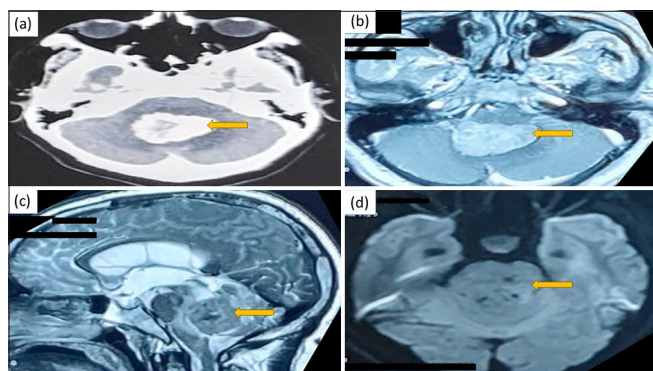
(a) Contrast-enhanced computed tomography showing a lobulated posterior fossa mass (yellow arrow) with heterogeneous enhancement. (b) Gadolinium-enhanced magnetic resonance imaging brain (axial view) showing a well-defined lobulated mass in the fourth ventricle with heterogeneous enhancement (yellow arrow). (c) T2-weighted imaging (sagittal view) showing the mass displaying iso- to hyperintense signal (yellow arrow). (d) Diffusion-weighted imaging sequence showing the tumour exhibiting patchy diffusion restriction (yellow arrow).
